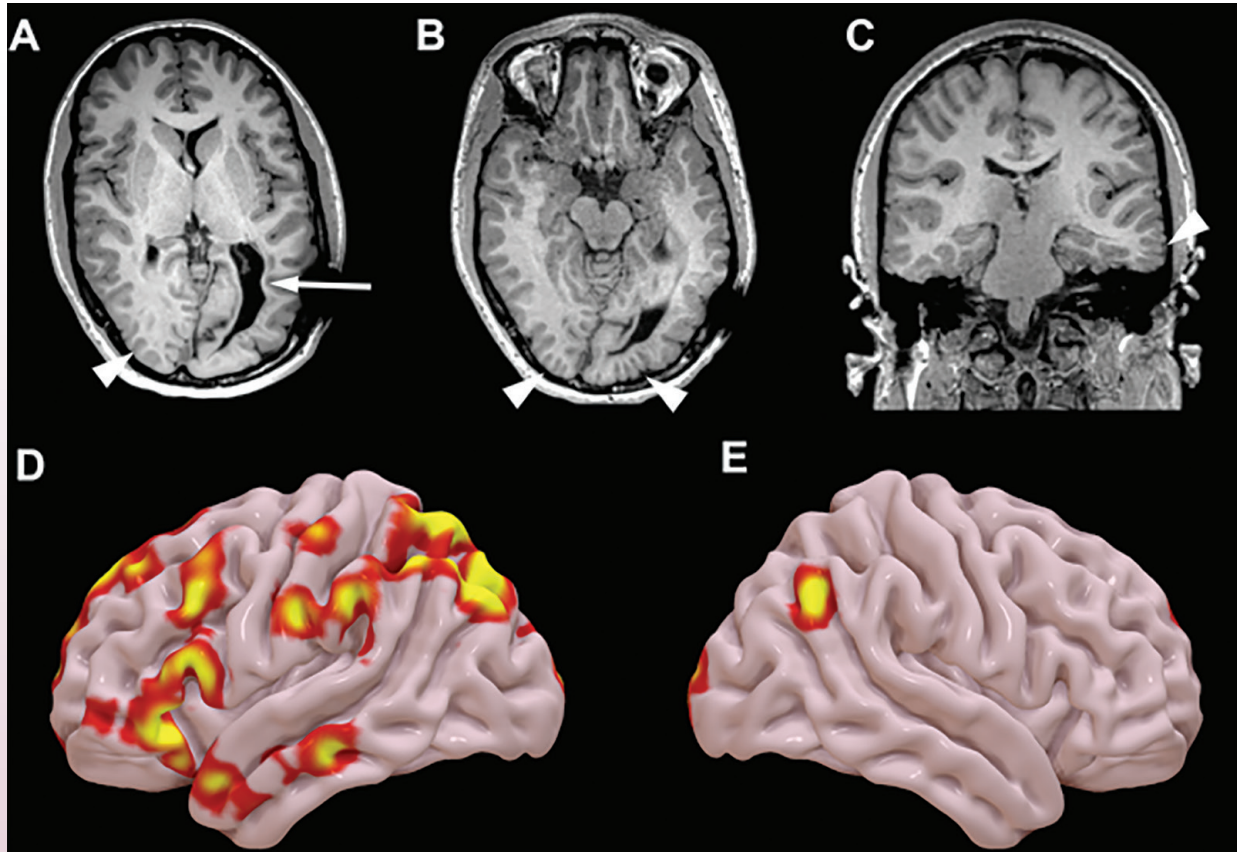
Axial (A,B) and coronal (C) T1-weighted images showing periventricular leukomalacia and associated enlargement of the left occipital horn and atrium of the lateral ventricle (arrow) with diffuse areas of abnormal sulcation and gyrification (arrowheads) throughout both hemispheres. Left (D) and right (E) hemisphere images of a functional MRI study using a sentence completion task shows strong left hemispheric dominance for language.
